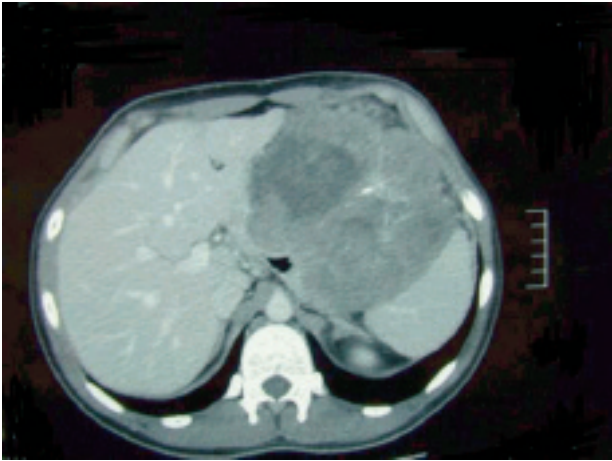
CT scan of the mass.
